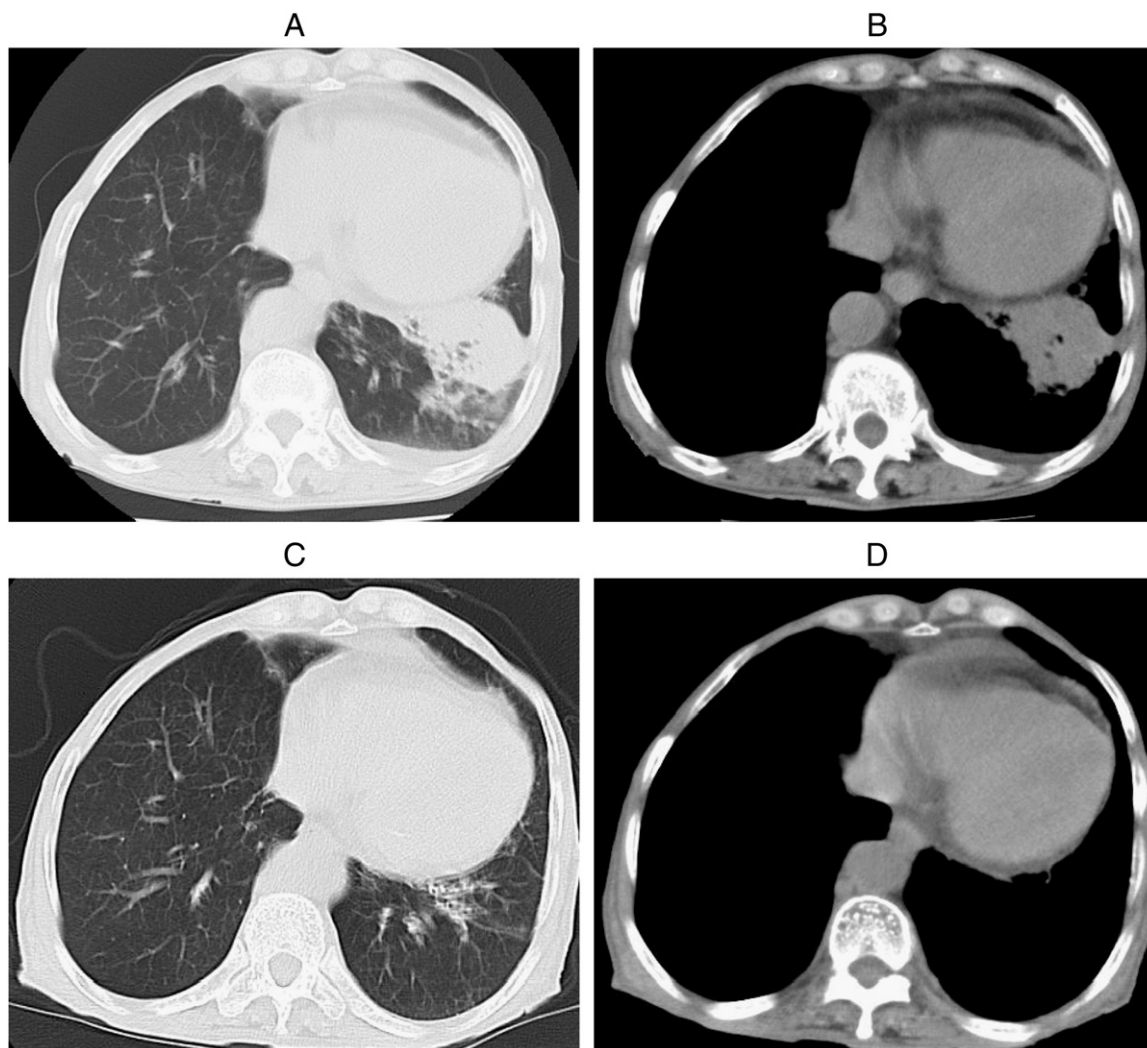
Chest CT demonstrated a mass-like lesion in the left lower lobe of the lung (A) and left pleural effusion (B). After 3 months of treatment with antibiotics, both the mass-like lesion and the left pleural effusion disappeared completely (C, D).
